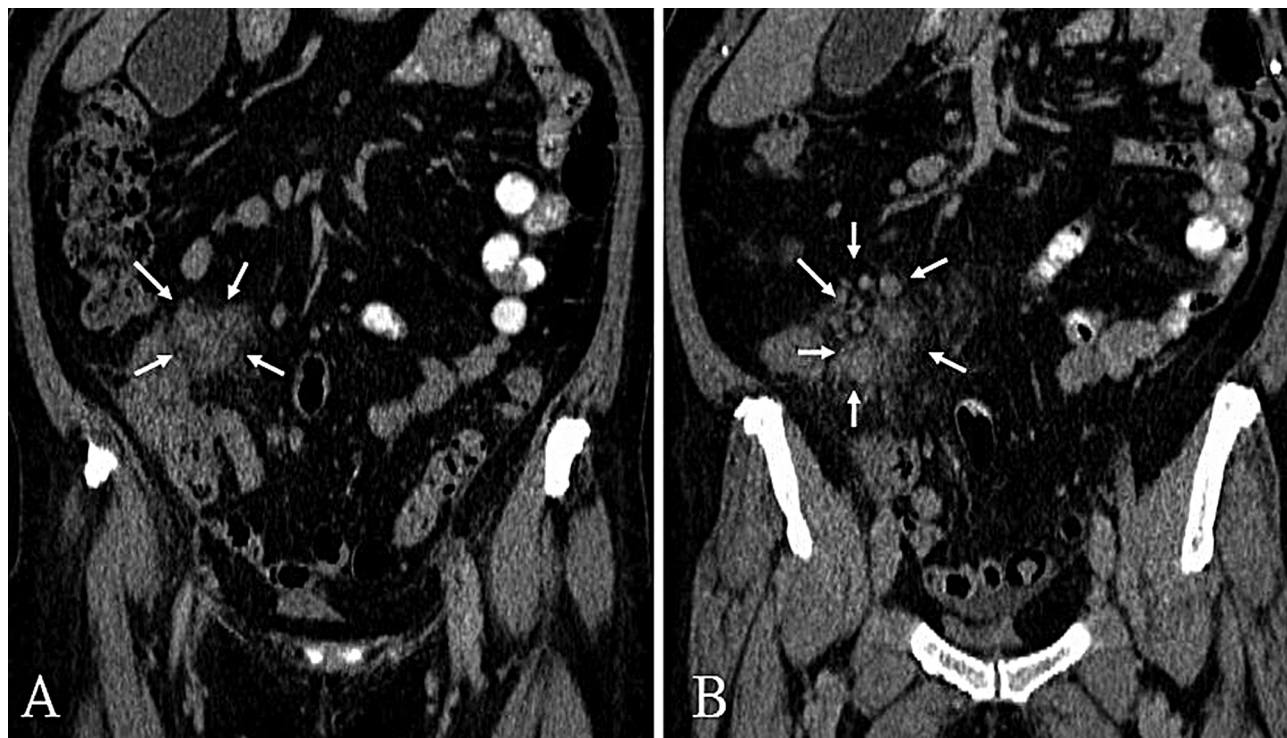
A coronal reconstruction view of the abdominal CT showing a conglomerate mass and multiple nodules close to the terminal ileum.
